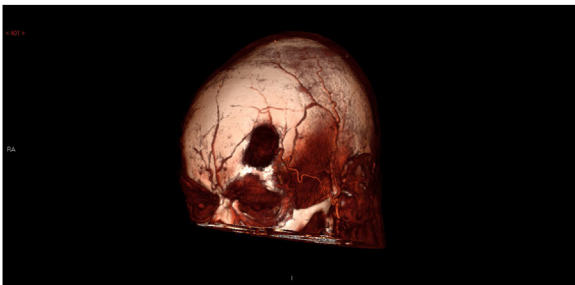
CT Angiography imaging of lesion.
